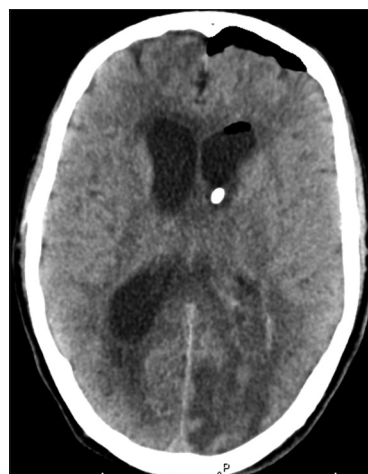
Computed tomography of the head used to confirm placement of the IRRFlow® catheter within the left lateral ventricle.
